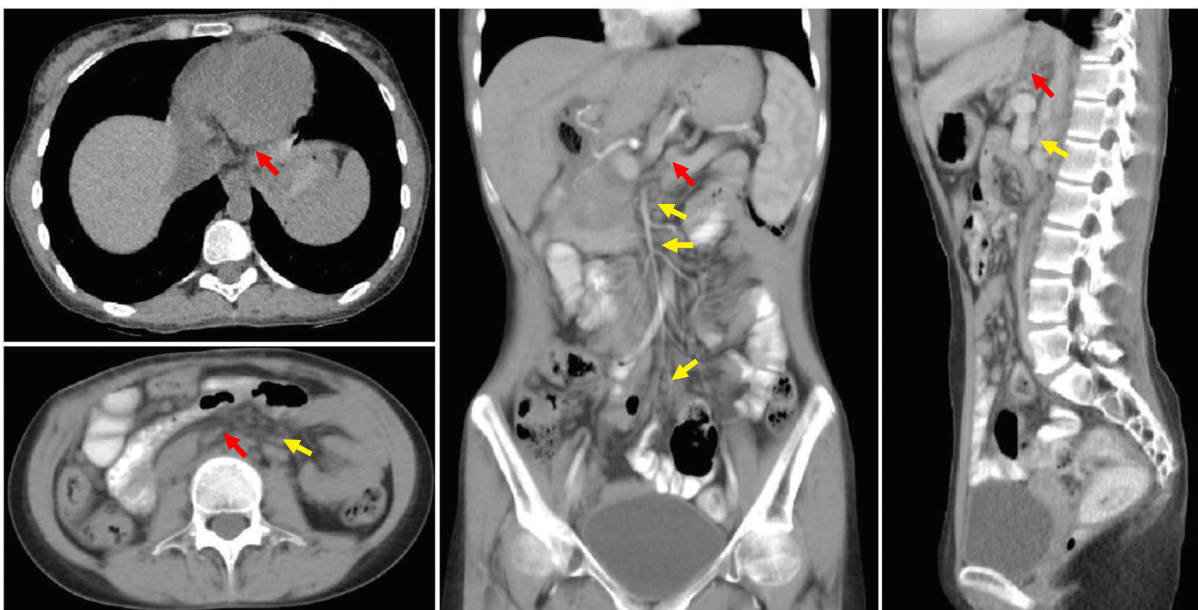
Postsurgical contrast-enhanced multislice computed tomography (MSCT) showing a recurrence of a pancreatic head mass (red arrows) attached to adjacent abdominal organs and several lymphadenopathies (yellow arrows)
